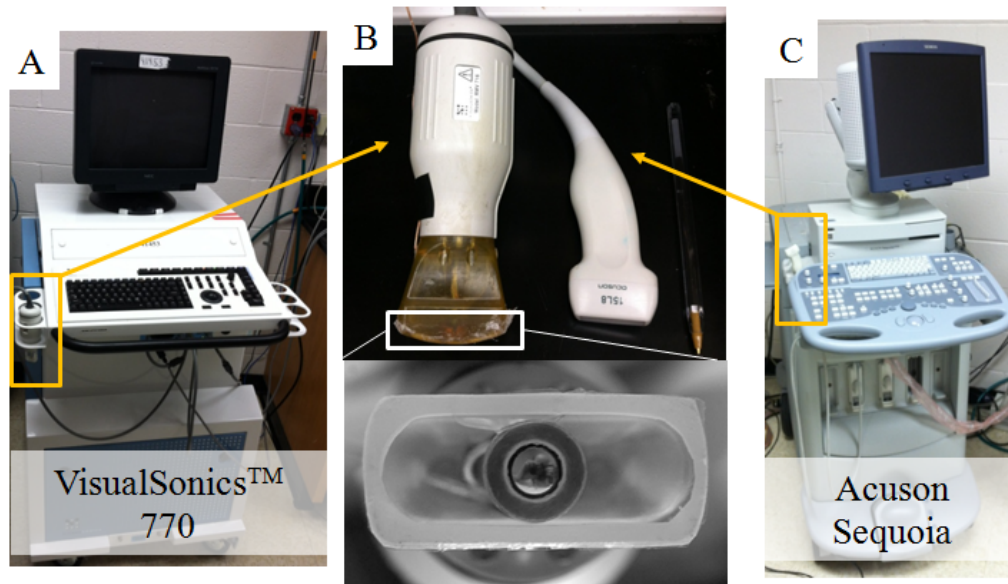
The ultrasound systems used to collect image data for this dissertation. A: The system used for acoustic angiography, B: Transducers for each system, C: The system used for CPS molecular imaging.
